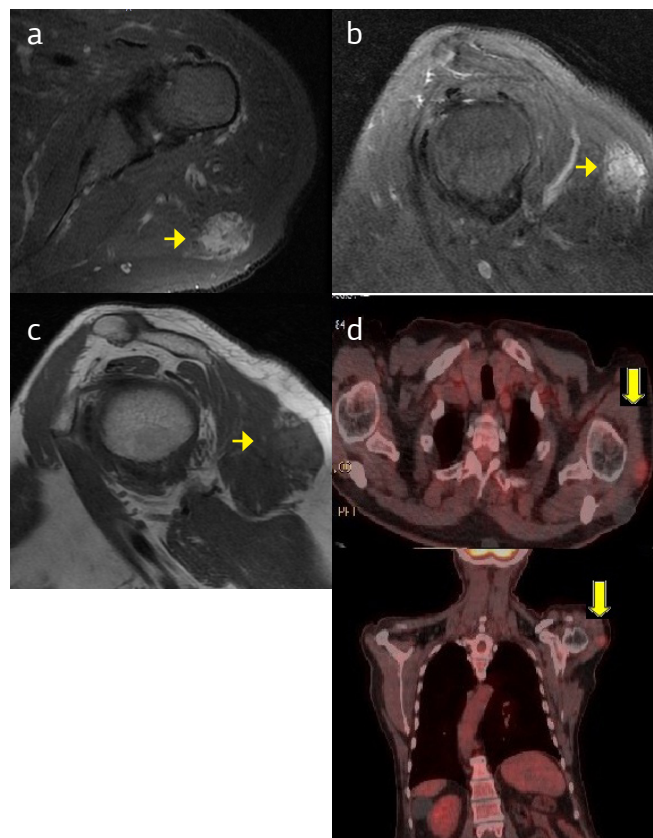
MRI shows a lesion, proximal portion of the deltoid muscle with high signal intensity on T2W1 (a and b) and low signal intensity on T1W1 (c), FDG-PET image shows hypermetabolic activity in the deltoid muscle with a maximum standard uptake value of 2.6 (arrowhead) (d).
